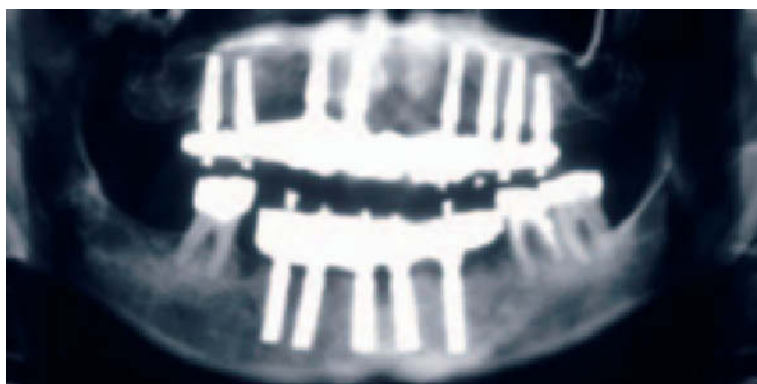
Panoramic radiograph after implant rehabilitation.
